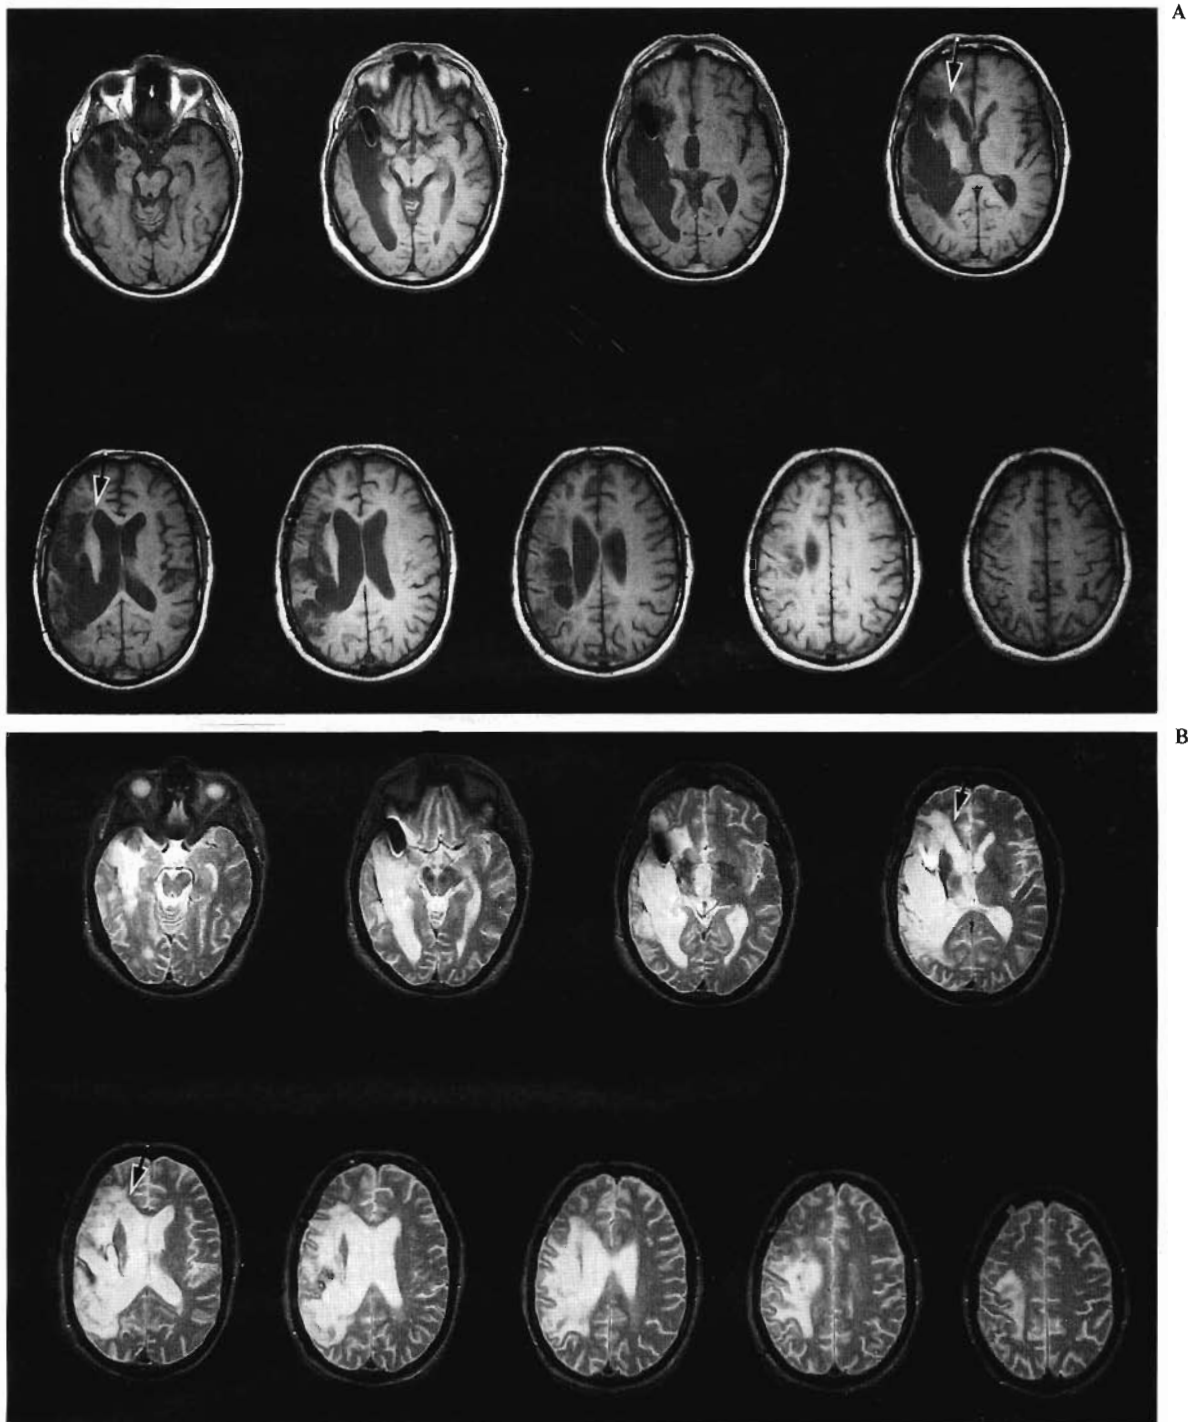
A: T1-weighted MRI images (TR, 600; TE, 20 ms) for patient SJ, performed 3 years postonset. These horizontal axial images do not show the lesion in the medial ScF area to touch the frontal horn on either of the first two slices where frontal horns are present (arrows). (MRI slice thickness was 5 mm, with a 2.5-mm gap.) The extent-of-lesion rating for the medial ScF area on the first two slices of these T1-weighted MRI images would be only 0 or 1. It has been our observation that T1-weighted images underestimate the borders of the lesion, especially near the ventricle, compared with a chronic CT scan performed at the same time postonset (Naeser et al., in preparation). B: T2-weighted images (TR, 2,000; TE, 80 ms) for patient SJ, performed 3 years postonset. These horizontal axial images *do* show the lesion in the medial ScF area to touch the frontal horn on both of the first two slices where frontal horns are present (arrows). The depth of the lesion in the medial ScF area on these T2-weighted MRI images is not in agreement with the depth of the lesion in the medial ScF area on the T1-weighted MRI images. If only the T1-weighted and the T2-weighted MRI images were performed and no CT scan images were performed, we would not know which set of MRI images to use for the extent-of-lesion rating analysis. We have observed that the T2-weighted MRI images tend to exaggerate the borders of the lesion, especially near the ventricle.
